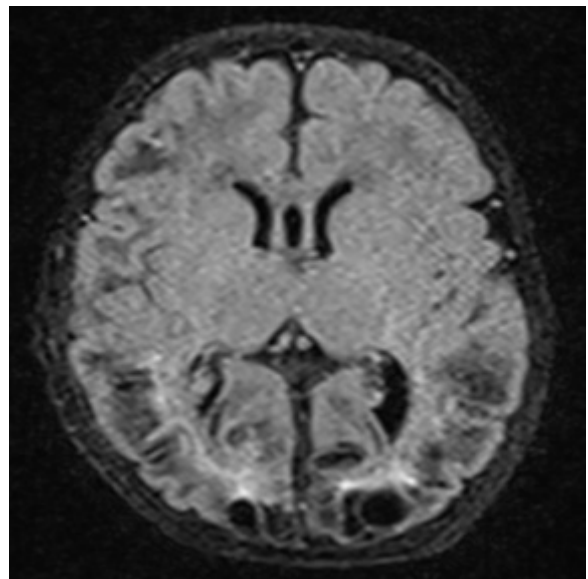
T2 FLAIR Axial image showing bilateral subcortical white matter hyperintensities and porencephalic cysts consistent with hypoxic-ischemic injury.
